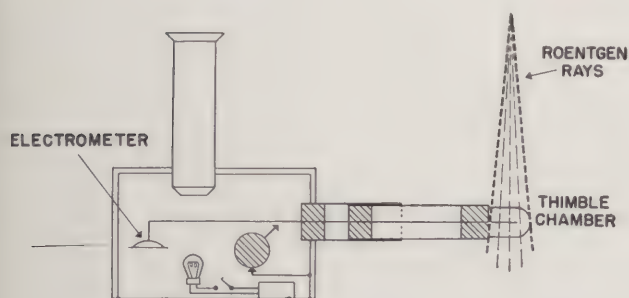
A secondary roentgen meter.
